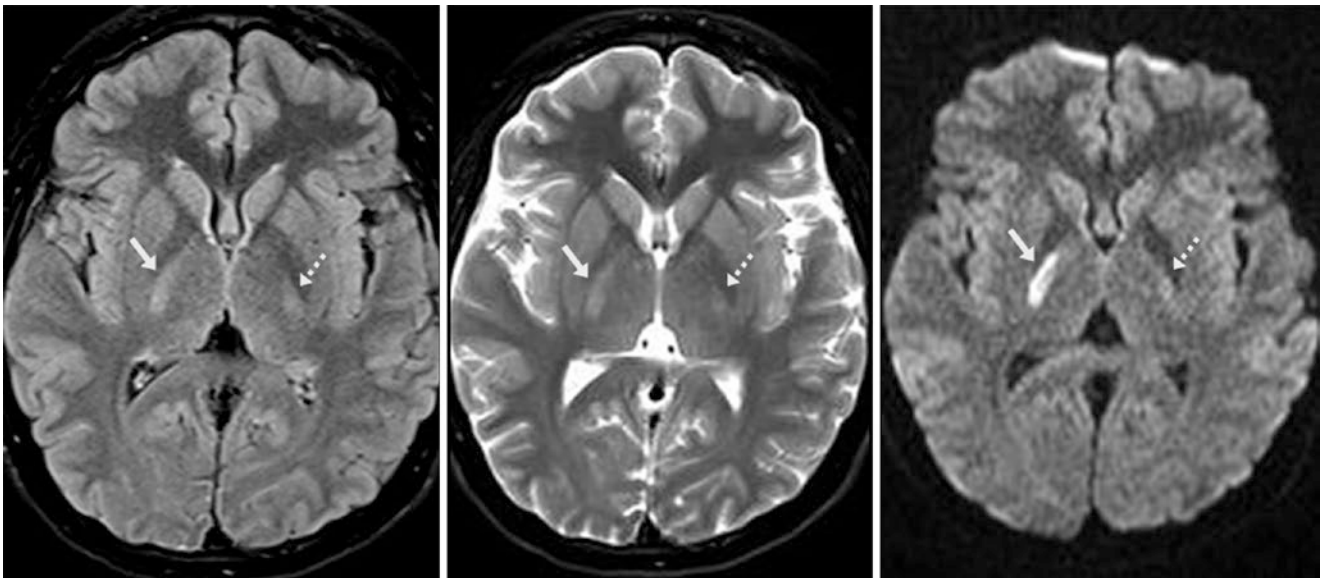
Comparison case of lacunar infarct. A 17-year-old had a 1.5 T MRI that showed a subtle CST lesion within the right PLIC (*arrows*) on FLAIR (*left*) and T2WI (*middle*). The lesion was brighter
